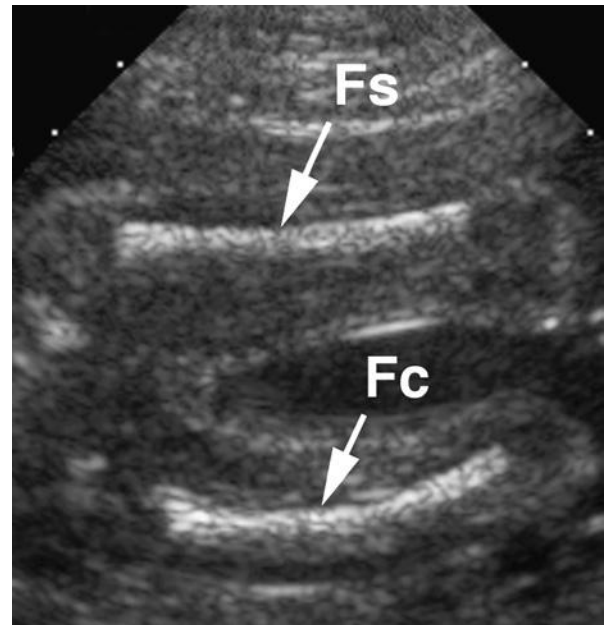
In this sonogram the diaphysis of the femur nearer to the transducer appears straight (Fs). The full thickness of the diaphysis is not seen. The diaphysis of the femur farther from the transducer appears curved (Fc). Compare with Figure 8-27. This is a normal shape of the medial aspect of the bone. However, the straight lateral cortex seen in the radiograph but not the sonogram visually compensates the curvature because the full thickness of bone is not perceived.
